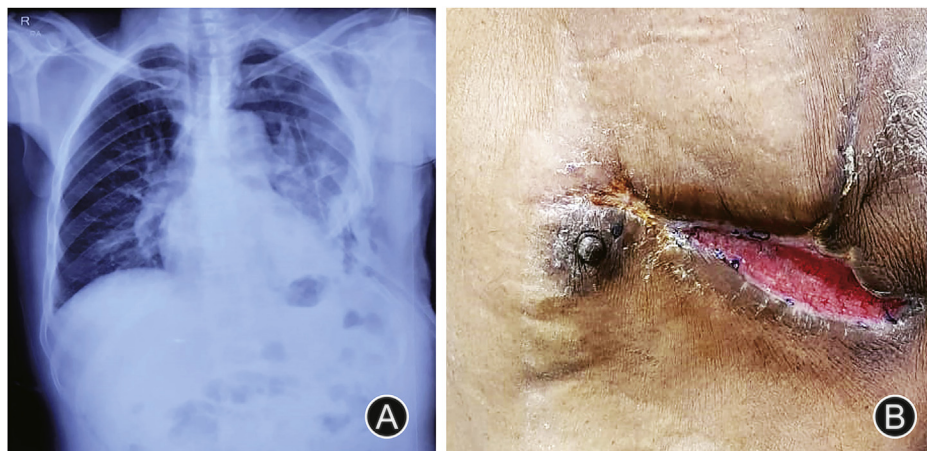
(A) Postoperative chest X-ray, posterior-anterior view; (B) Healing by primary intention after one month at the site of flap necrosis.
